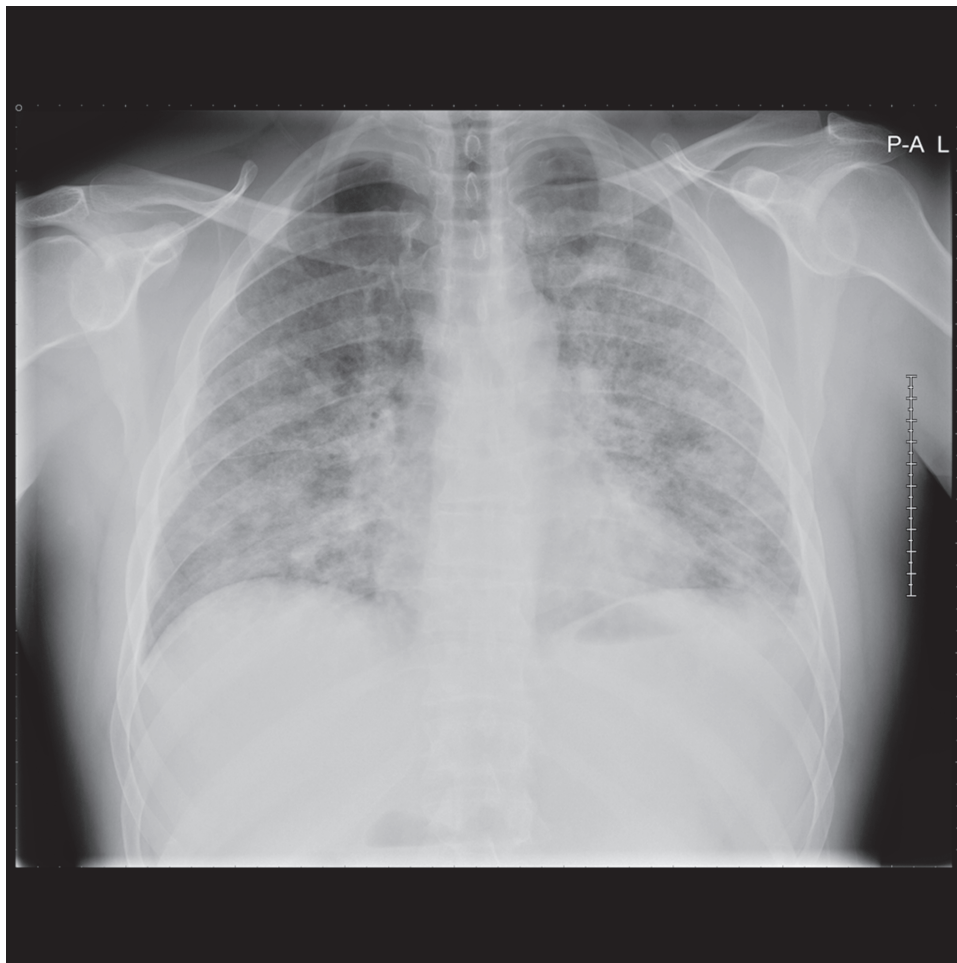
Radiograph the day after admission, showing extensive bilateral alveolar consolidations.
